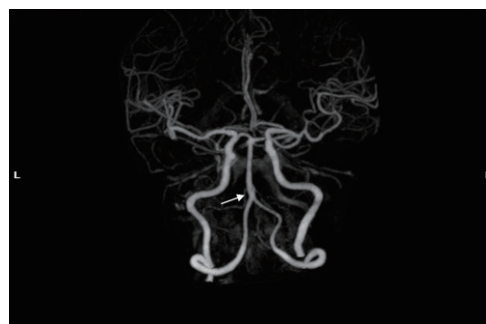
Brain computed tomography angiography: a fenestration of the proximal basilar artery (white arrow).
